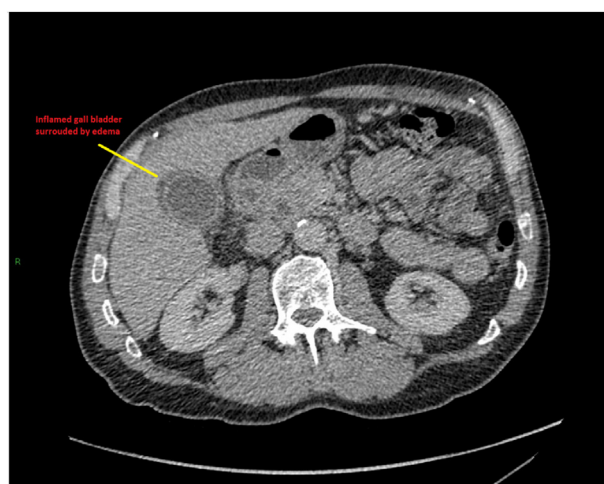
Abdominal CT scan axial view showing the gallbladder.
